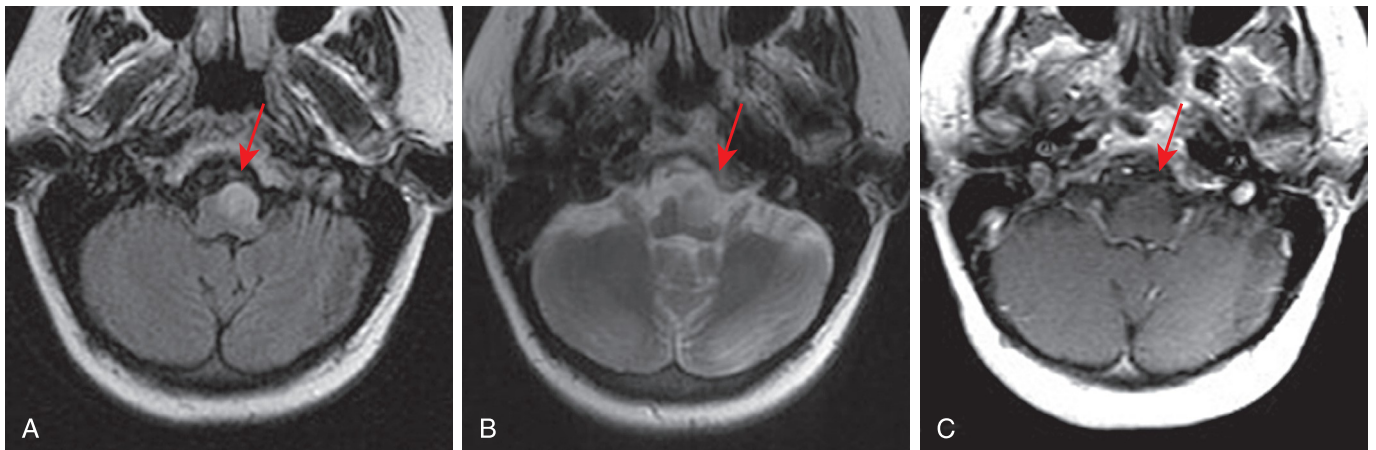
A middle-aged woman with known history of brainstem glioma. Axial fluid-attenuated inversion recovery (FLAIR) (A), axial T2 (B), and axial T1 postcontrast images (C) demonstrate a nonenhancing T2/FLAIR hyperintense mass (arrows) larger than expected in size for hypertrophic olivary degeneration and extending beyond the expected anatomic margins of the left medullary olive.
